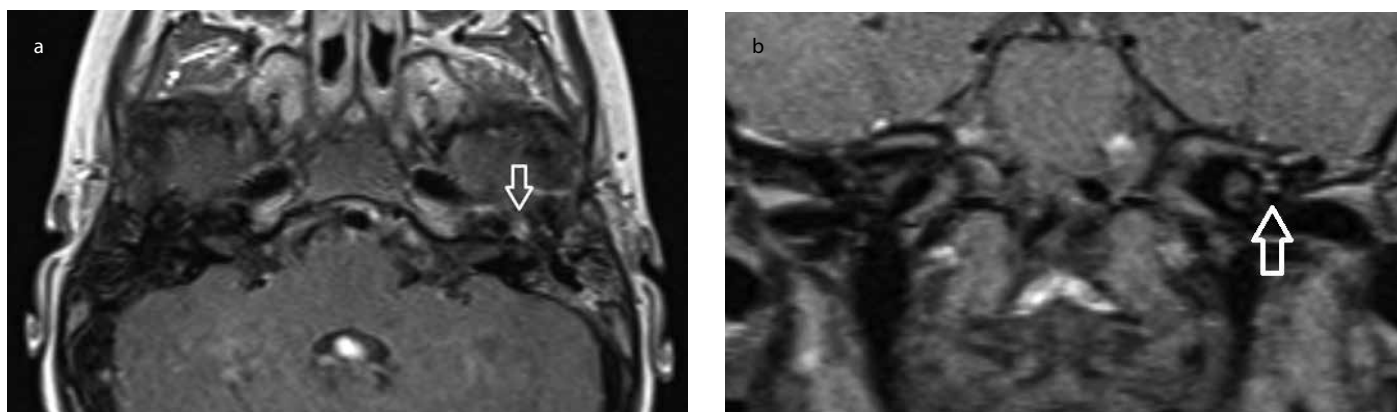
a, b. MRI of the skullbase shows slight enhanced signal at the geniculate ganglion on the left side. A subtle finding found on the axial and coronal slides
